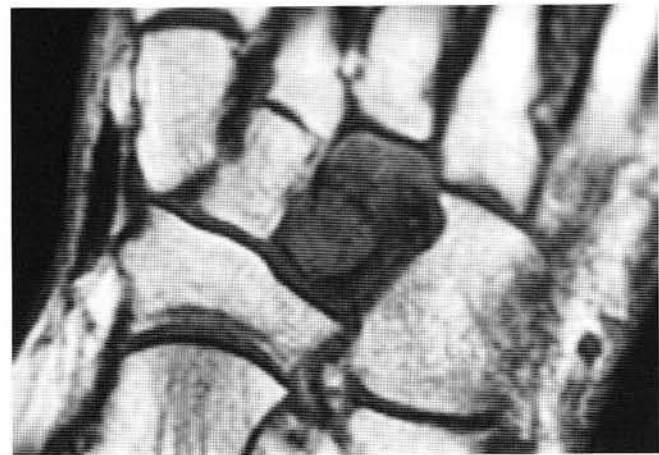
Magnetic Resonance imaging scans of the foot. Axial T1-weighted image of the left midfoot shows low signal (dark) in the entire lateral cuneiform with a well circumscribed one centimeter lesion area in the proximal cuneiform.
